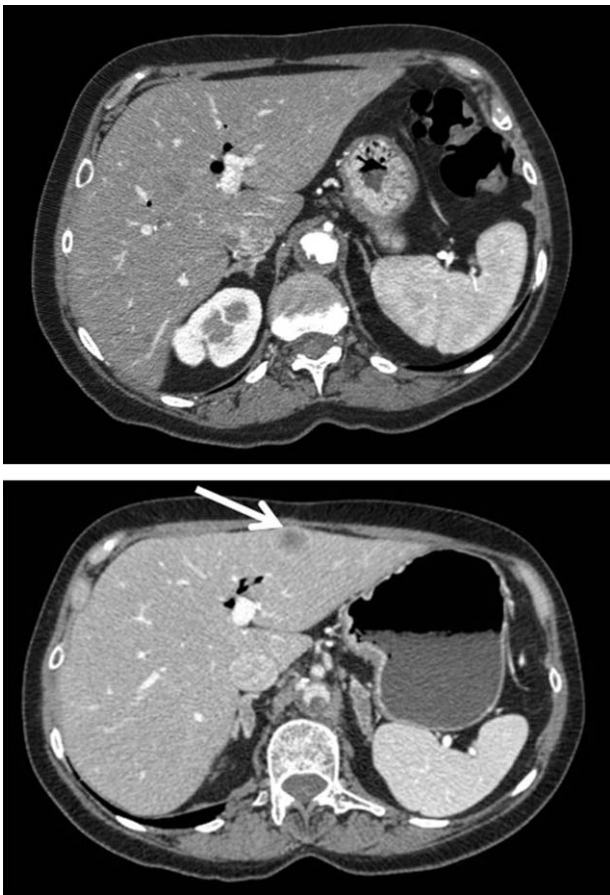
(Top) Axial computed tomography section from a 60-year-old patient with biopsy-proven pancreatic adenocarcinoma shows pneumobilia related to a biliary stent, but no lesions within the liver. (Bottom) A follow-up study 20 months later shows a new low-attenuation lesion (arrow) within the left lobe of the liver. Biopsy of this lesion was positive for metastatic adenocarcinoma.
